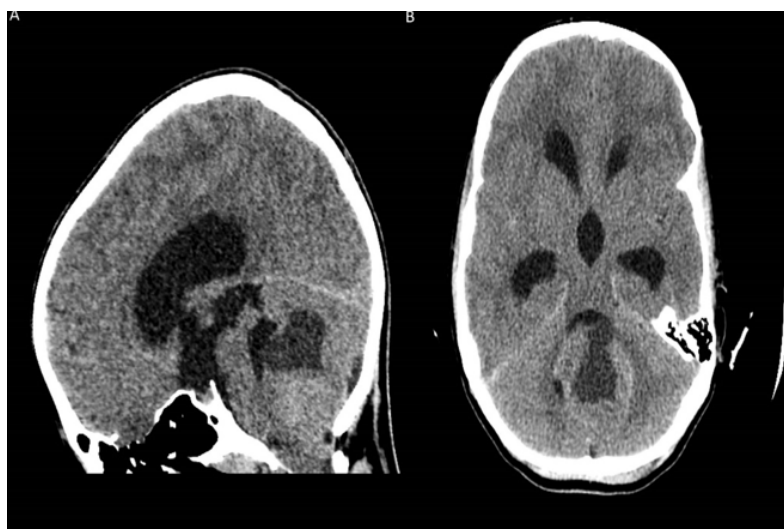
Initial CT examination.
